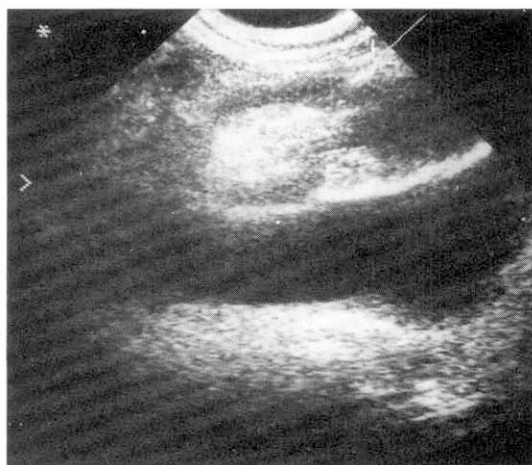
Abdominal ultrasonogram shows echogenic lesion in supramesocolic space.
